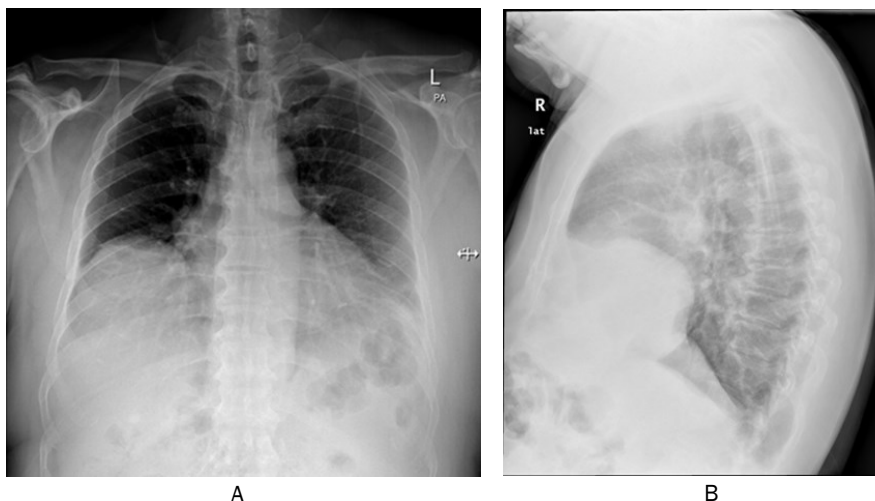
Postero-anterior (A) and lateral view chest x-ray showing homogenous lobulated opacity in right lower zone
